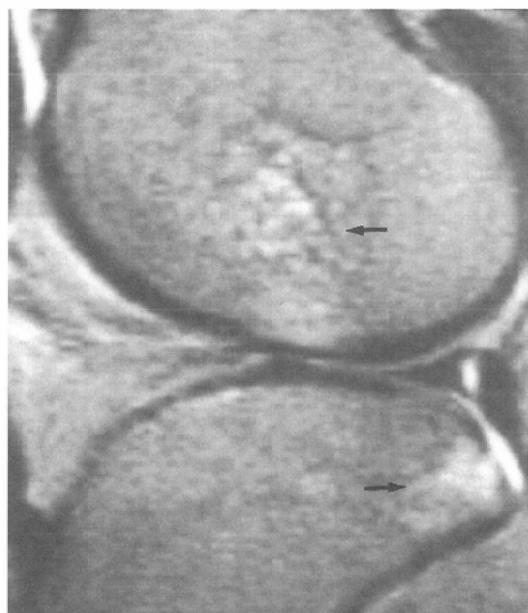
MR images of the knee of 17 year-old female with torn posterolateral band of ACL with bone bruise proved at arthroscopy. Proton-density- (A) and T2-weighted (B) sagittal images (2000/20,80) shows discontinuity of the ACL (arrow head). Bone bruise is seen in the middle third of the lateral femoral condyle and the posterior aspect of the lateral tibial plateau (arrow) on T2-weighted sagittal image (C).
